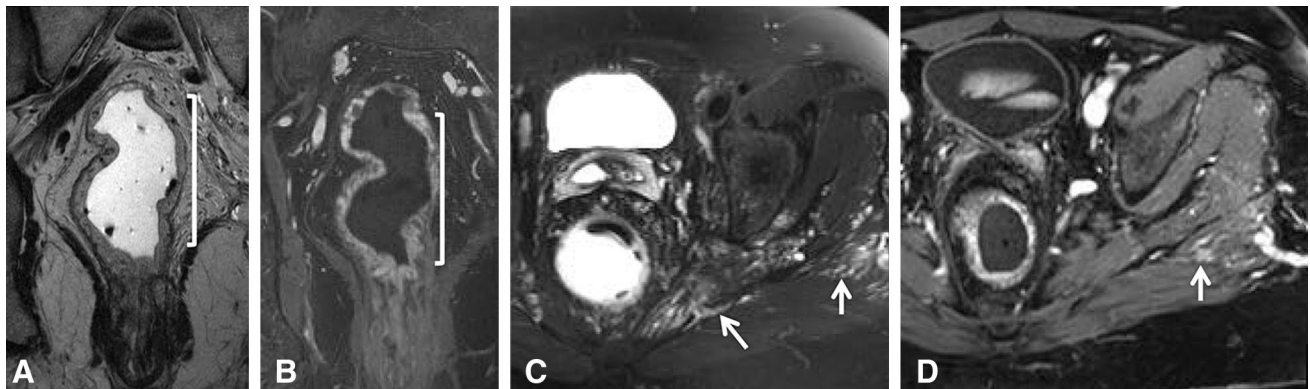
Rectal wall hemangioma in a patient with Klippel–Trenaunay–Weber syndrome. Rectal gel is present on all images. A Coronal T2-weighted image shows multiple flow voids (bracketed) within the rectal wall that also enhance, as seen on B coronal T1-weighted post-contrast image. These
